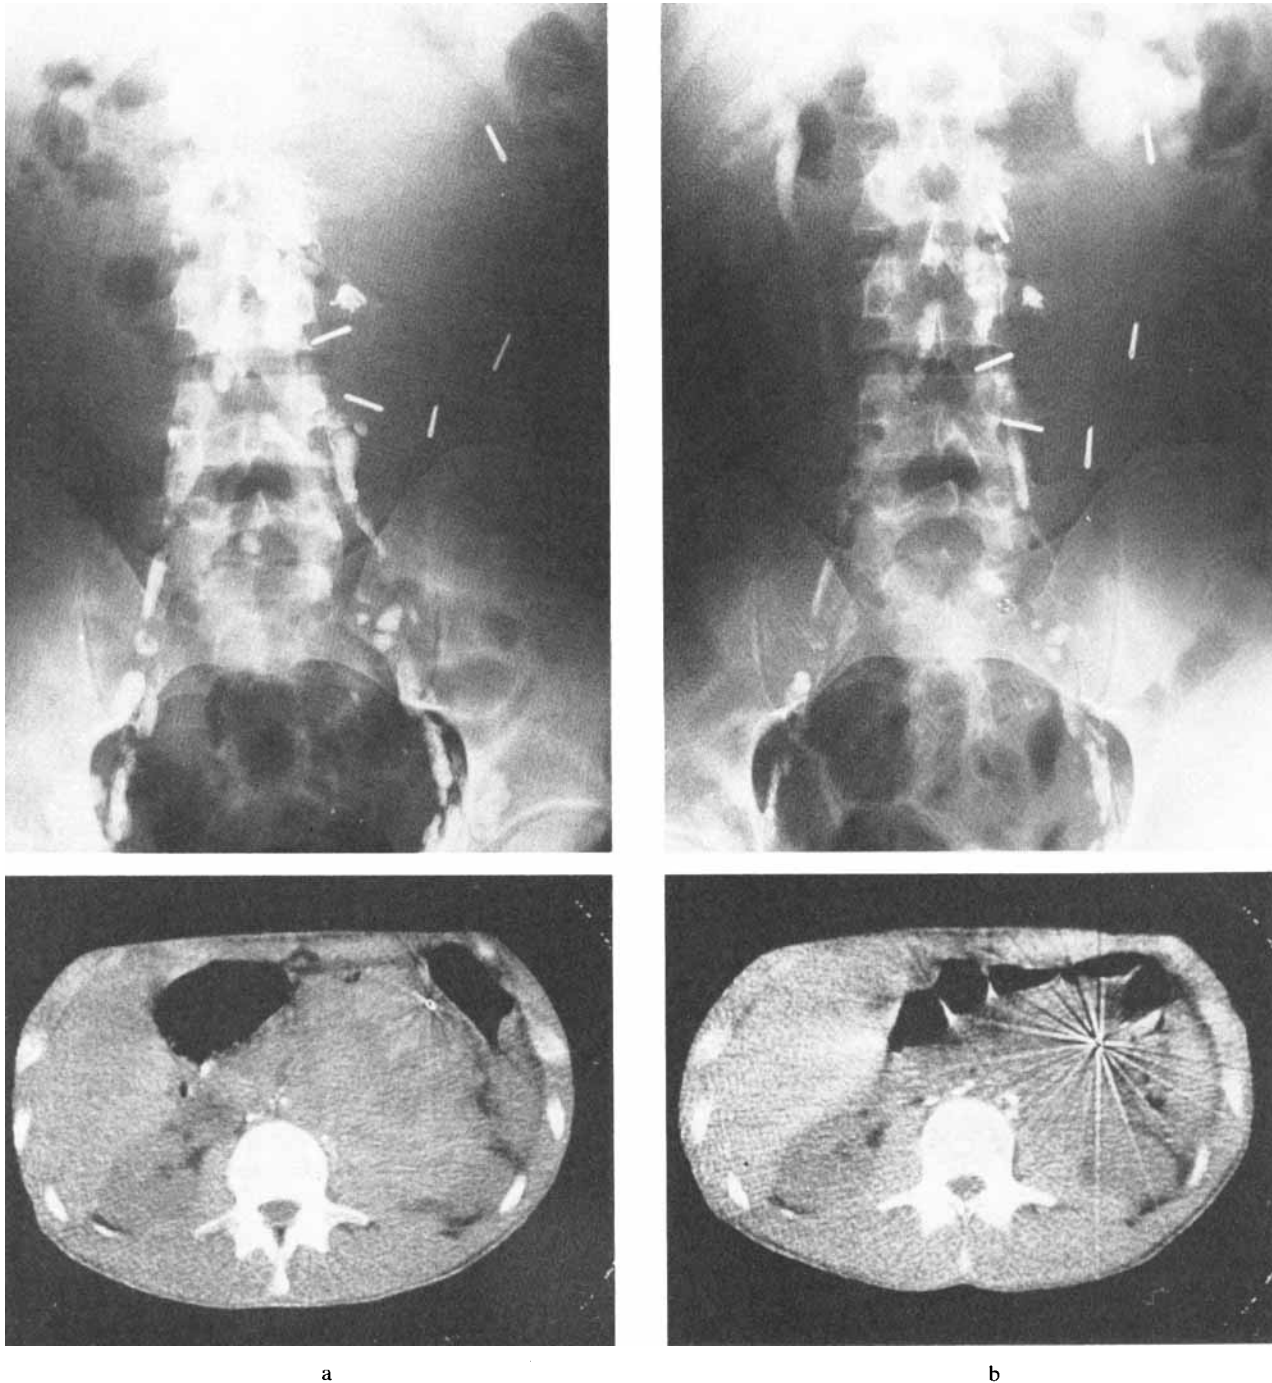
25-year-old. Anaplastic seminoma of the left testis, with a huge mass in the left lumbar region, whose contours were marked with metallic clips at laparotomy. CT and survey films of the abdomen were performed before irradiation (a) and repeated after 20 Gy (b) in an attempt to reduce the field size. CT
